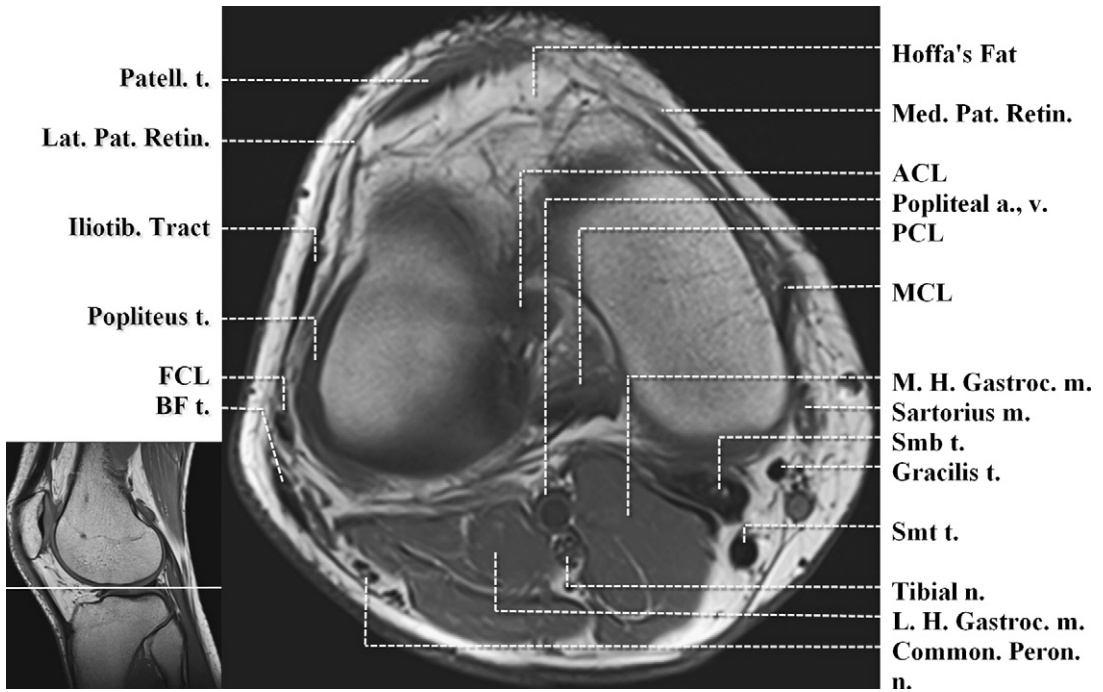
Axial T1-weighted image. Femorotibial joint space. a., artery; ACL, anterior cruciate ligament; BF LH. t., SH m., biceps femoris short head muscle, long head tendon; Comm. Peron. n., common peroneal nerve; FCL, fibular collateral ligament; Iliotib., iliotibial; m., muscle; MCL, medial collateral ligament; M.H./L.H. Gastroc., medial and lateral heads of gastrocnemius; Med./Lat. Pat. Retin., medial and lateral patellar retinacula; n., nerve; Patell. tend., patellar tendon; Smb, semimembranosus; Smt, semitendinosus; t., tendon; v., vein.
